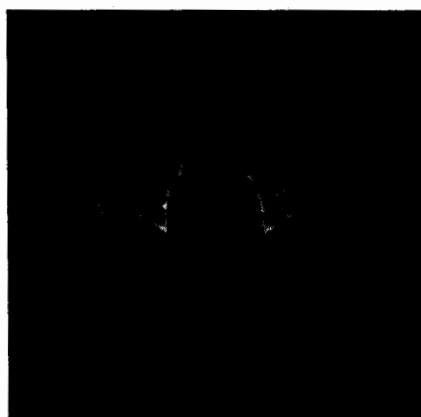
Registered CT image of Pelvis with MRI by Image Registration described in MATLAB©
